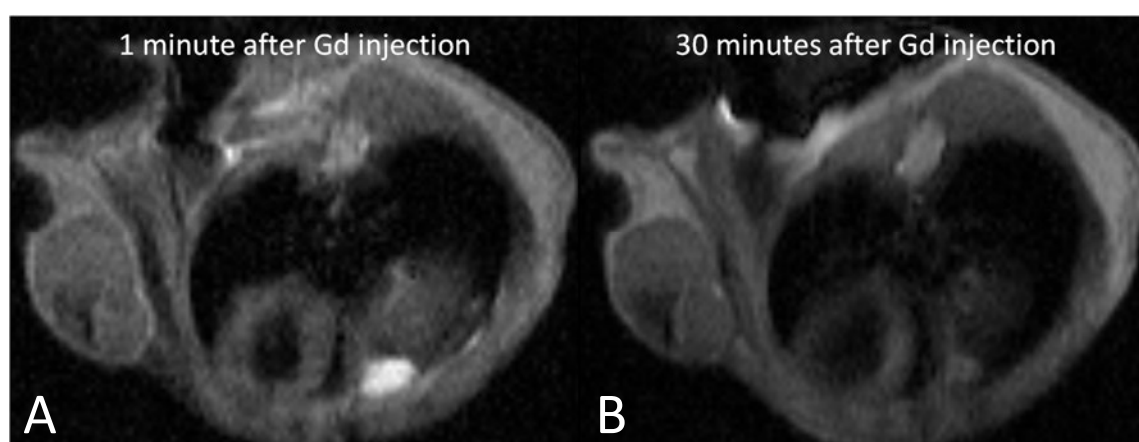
examples of MRI acquisition and administration of gadolinium: A) one minute after Gd injection; B) 30 minutes after Gd injection.
